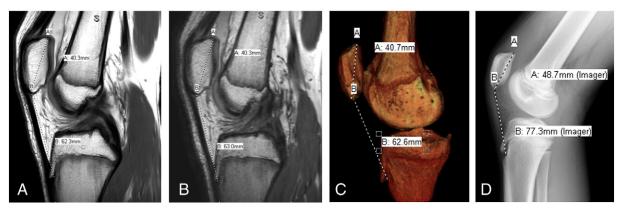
Insall–Salvati ratio on 2D proton density (PD) (A), 3D PD (B), 3D model (C), and lateral X-ray (D) of knee. Notice that the X-ray measurement is different than the MR and 3D model measurements but ratios are similar (1.53 on 3D model vs. 1.58 on X-ray).
